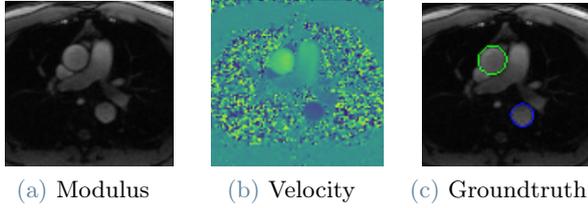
Images embedded in a DICOM file - Modulus, Velocity and Groundtruth on the time-resolved modulus image of a cine MRI
